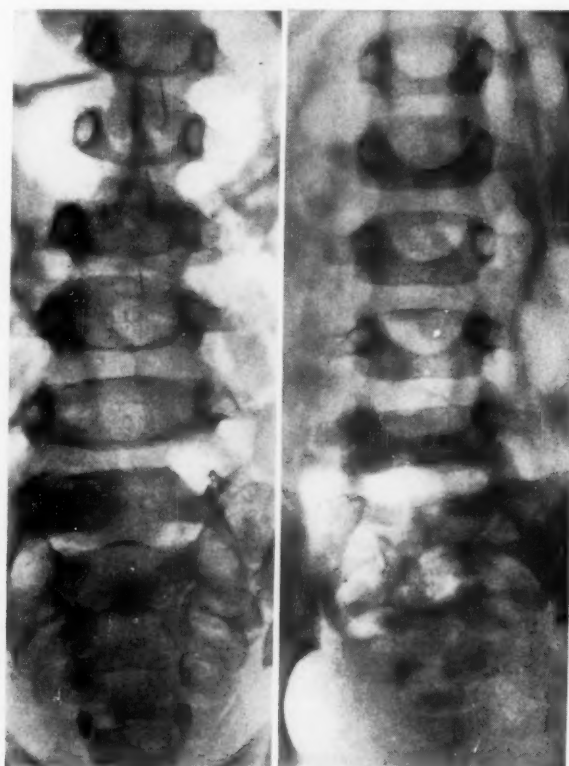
On the left is a reproduction of the roentgenogram of the lumbosacral spine of the patient with an intramedullary dermoid cyst. On the right a roentgenogram of a normal lumbosacral spine in a child of the same age has been reproduced for comparison. The dilatation of the spinal canal without any appreciable thinning or deformity of the pedicles is clearly shown.
